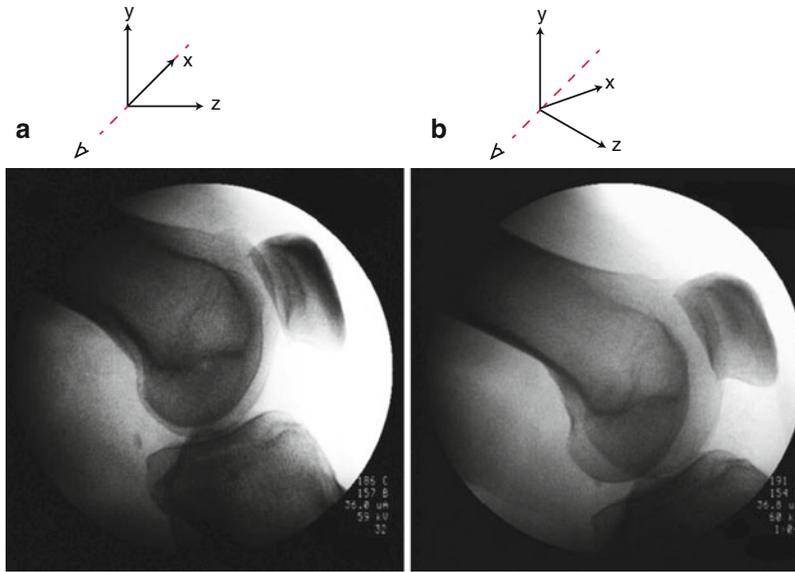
A simple example of spillover occurs when a true lateral radiograph (a) is rotated slightly resulting in an offset view (b), thus making it harder to interpret
